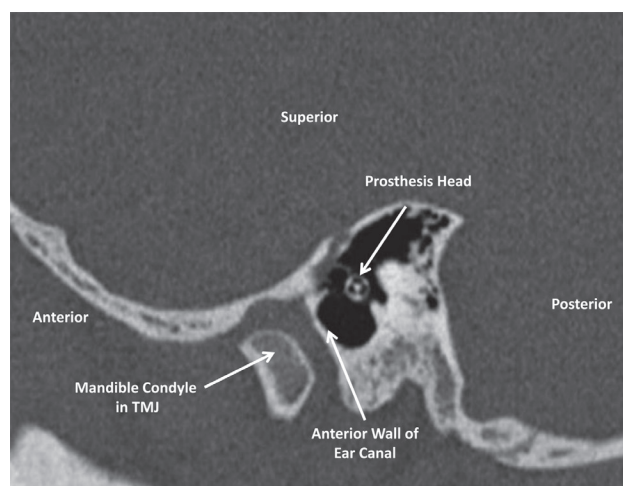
Sagittal CT image (similar to looking into the ear canal) showing the head of the prosthesis is not fixed to the tympanic ring.
